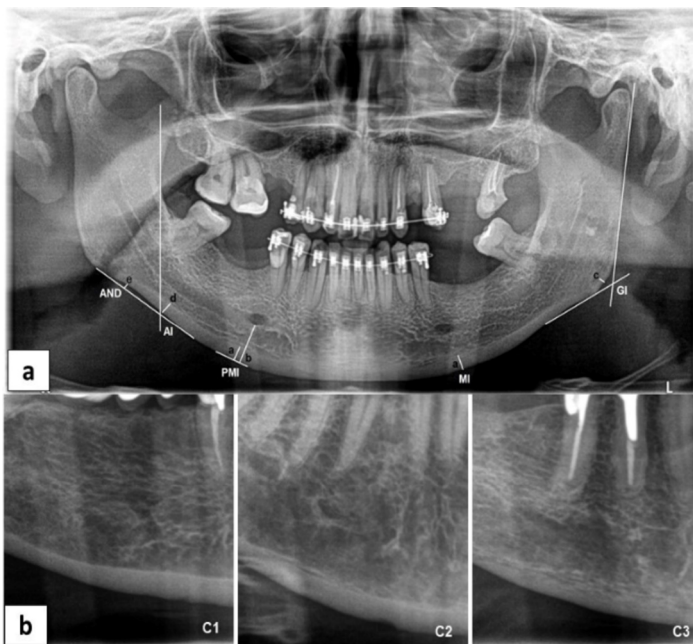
a) Panoramic radiograph with the measuring method used for the Panoramic mandibular index (PMI), mental index (MI), antegonial index (AI), goniac index (GI), antegonial notch depth (AND); b) Cropped panoramic radiographs showing the C1, C2, and C3 classification of the mandibular cortical index
